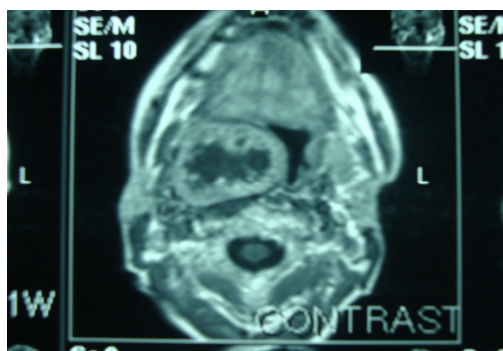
MRI of the right parapharyngeal space with heterogeneous enhancement.
